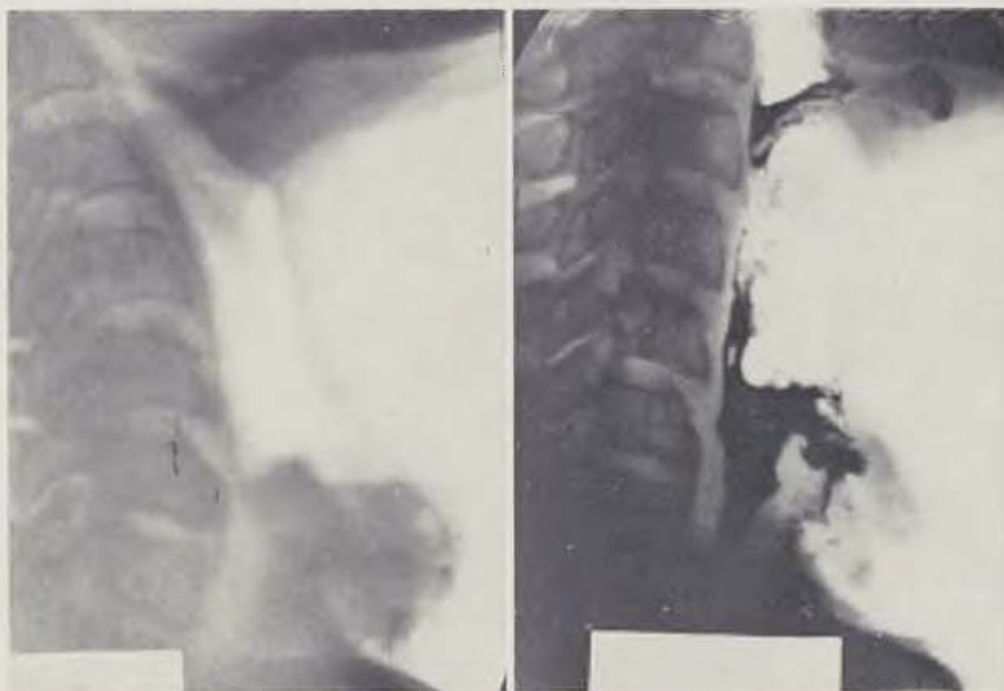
X-ray photographs of patient S. Consequences of a neck injury (pharyngotomy subhyoidea). A diastasis is seen between the hyoid bone and the larynx. The baryum suspension gets into the respiratory pathways, when swallowed
